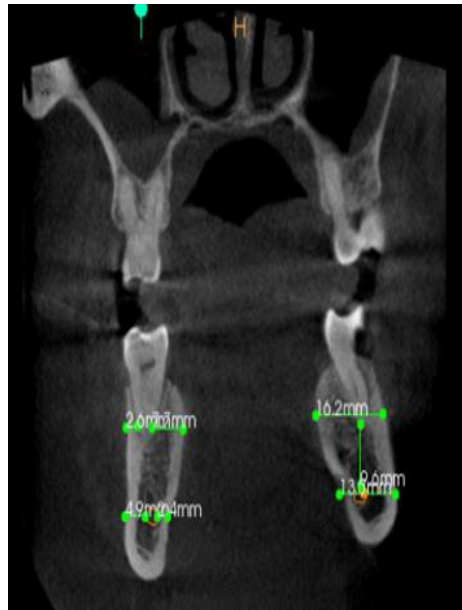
Examples of the 7 different measurements taken for both the mesial and distal roots of the mandibular first molar on (Coronal view) CBCT Scan.
